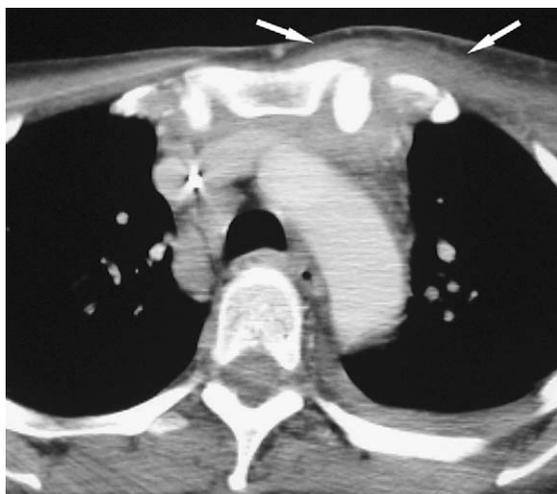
A 45-year-old female intravenous drug user with septic arthritis. Contrast-enhanced CT image (7-mm collimation) shows swelling of the soft tissues adjacent to the left sternoclavicular joint (arrows). Culture of joint aspirate grew *Staphylococcus aureus* confirming septic arthritis. Bone scintigraphy was negative for osteomyelitis or other sites of involvement.
